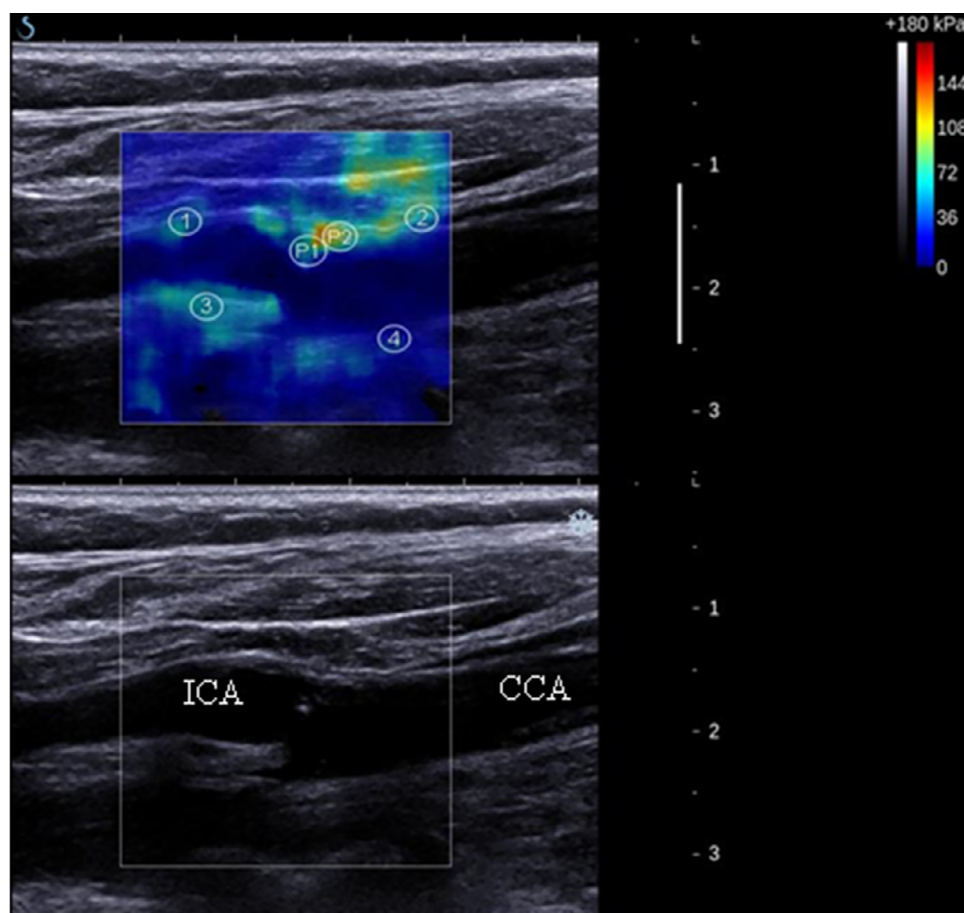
Example of quantitative stiffness assessment using a commercial ultrasound system (Aixplorer SuperSonic, Aix-en-Provence, France) in a patient with a stenosis of 30%–40% at the origin of the internal carotid artery. Left: B-Mode image with the internal carotid artery (ICA) and common carotid artery (CCA). Right: Elastogram of the ICA and CCA with six 2-mm circular regions of interest in the anterior (2) and posterior (4) CCA, the anterior (1) and posterior (3) ICA, within the plaque (P1 and P2). (Reprinted with permission from Ramnarine et al. [2014b], published under the terms of the Creative Commons Attribution License [<http://creativecommons.org/licenses/by/4.0/>]).
